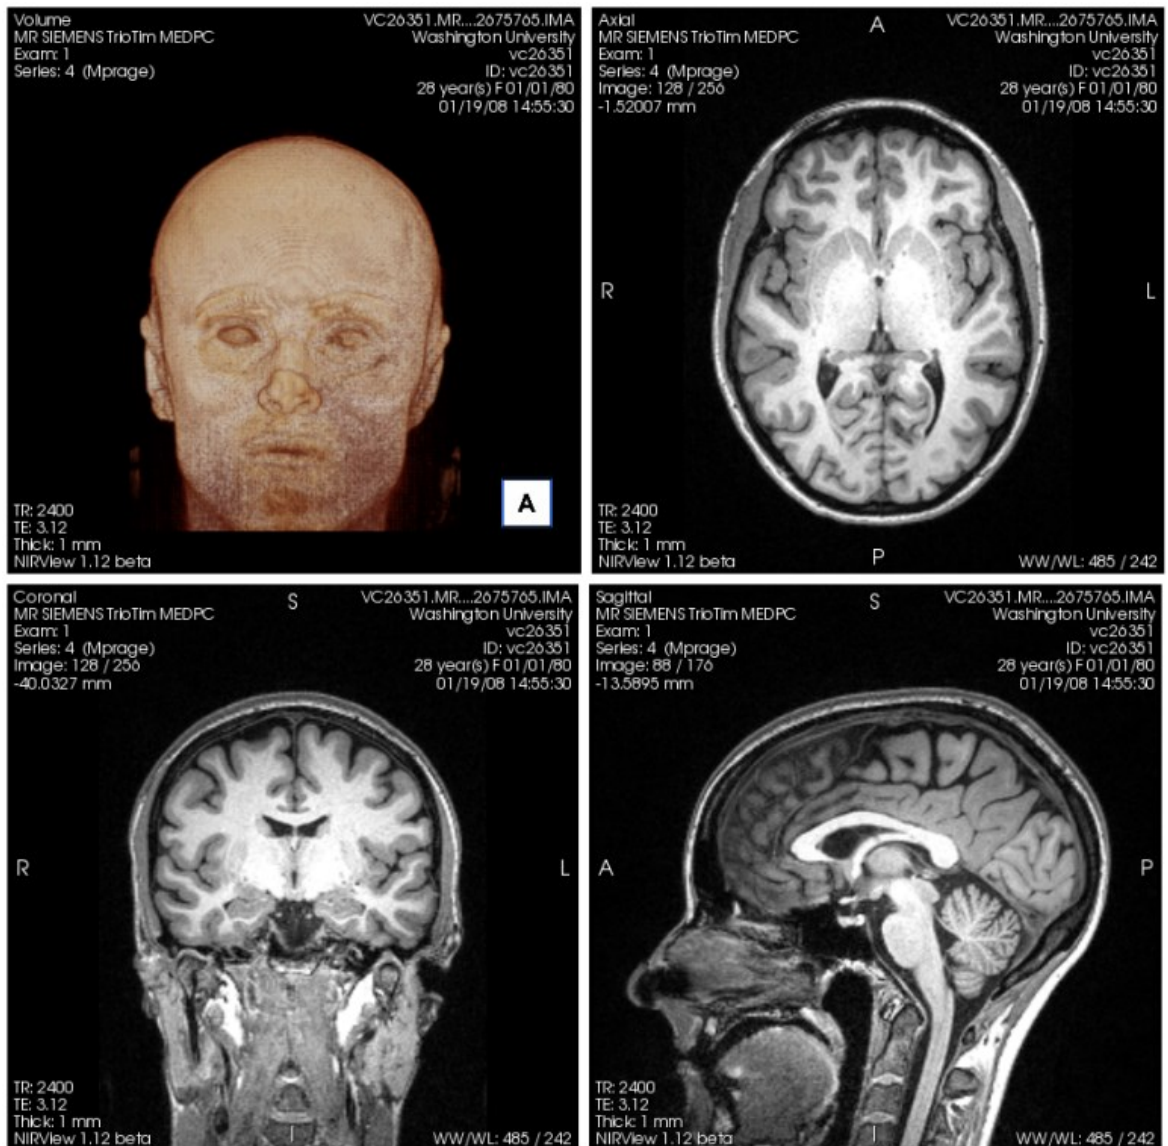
A set of 3D MRI head images from a healthy young adult and its 3D rendering.
